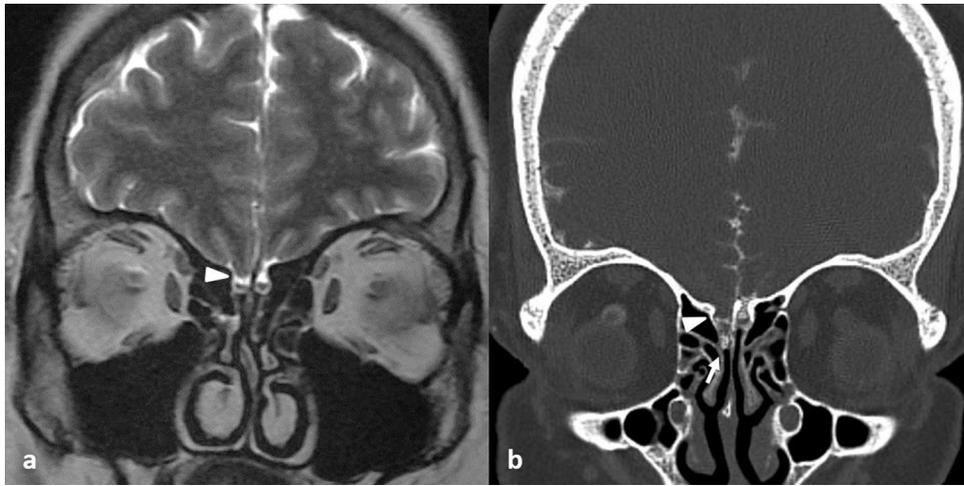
Forty-year-old woman with watery discharge from right nasal cavity. Low-lying gyrus rectus sign: a–b: coronal CT and MR cisternography images show decreased distance between gyrus rectus and olfactory bulb on right side (arrow head) with CSF leak into the right nasal cavity through cribriform plate (arrow).
